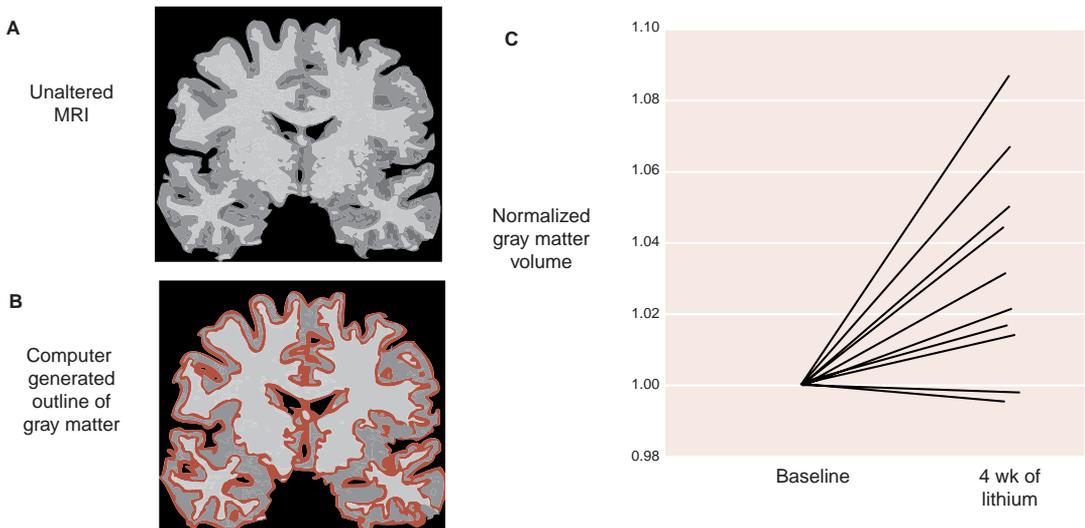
● Gray matter in magnetic resonance imaging (MRI) (A) is outlined and quantified in the computer (B). The change in gray matter volume for each subject is shown after 4 weeks of lithium (C) (Adapted from Moore GJ, Bebhuk JM, Wilds IB, et al. Lithium-induced increase in human brain gray matter. *Lancet*. 2000;356(9237):1241-1242.)
